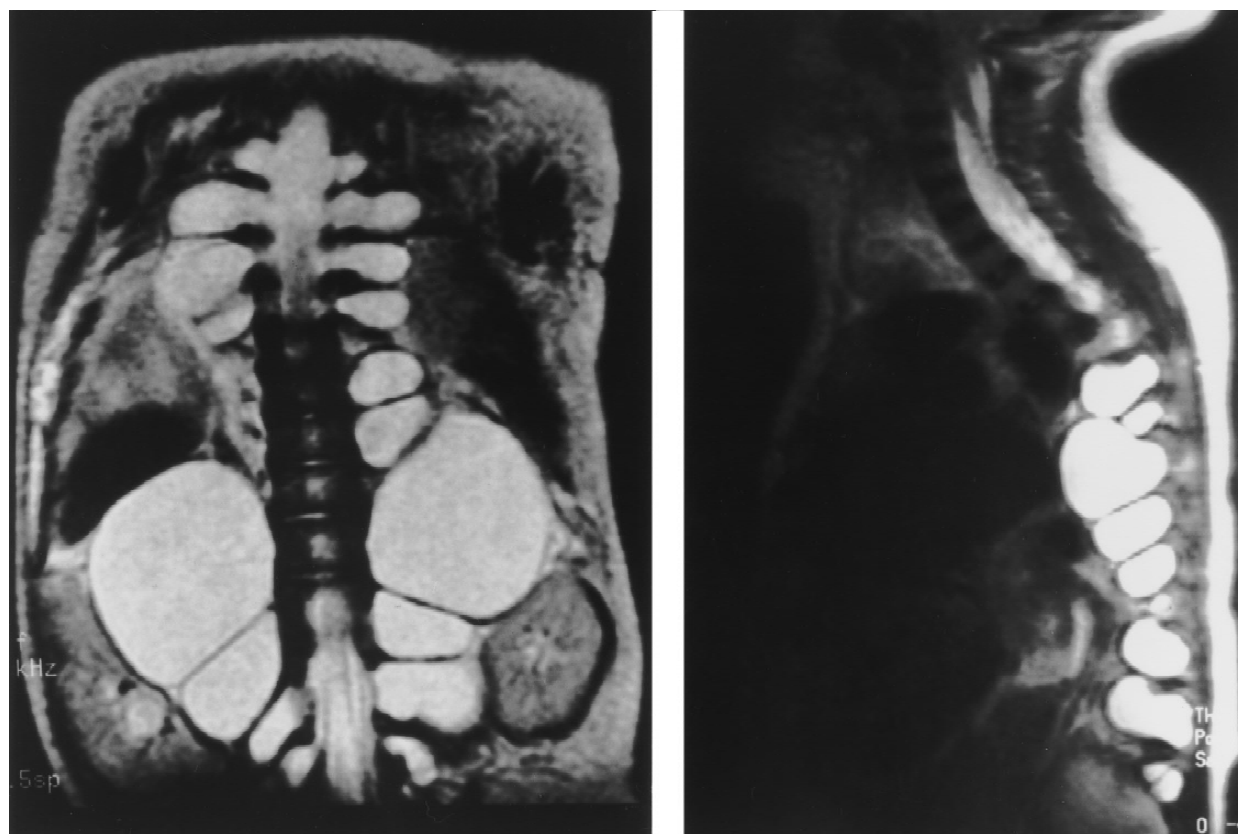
Coronal and sagittal T2-weighted MR images of the thoraco-lumbar spine of patient 1 show multiple bilateral meningoceles, widening of the spinal canal, and enlarged neural foramina. Lumbar meningoceles displace the kidneys laterally.
